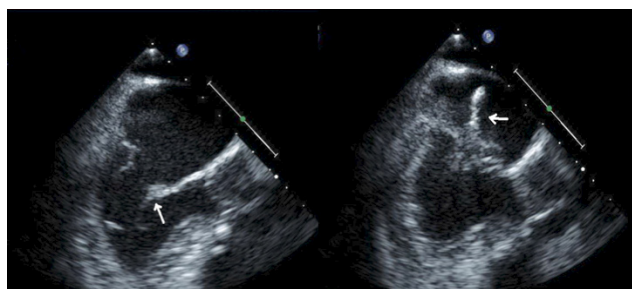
The mobile vegetation on the mitral valve seen at trans-esophageal echocardiography is pointed by the white arrow.
